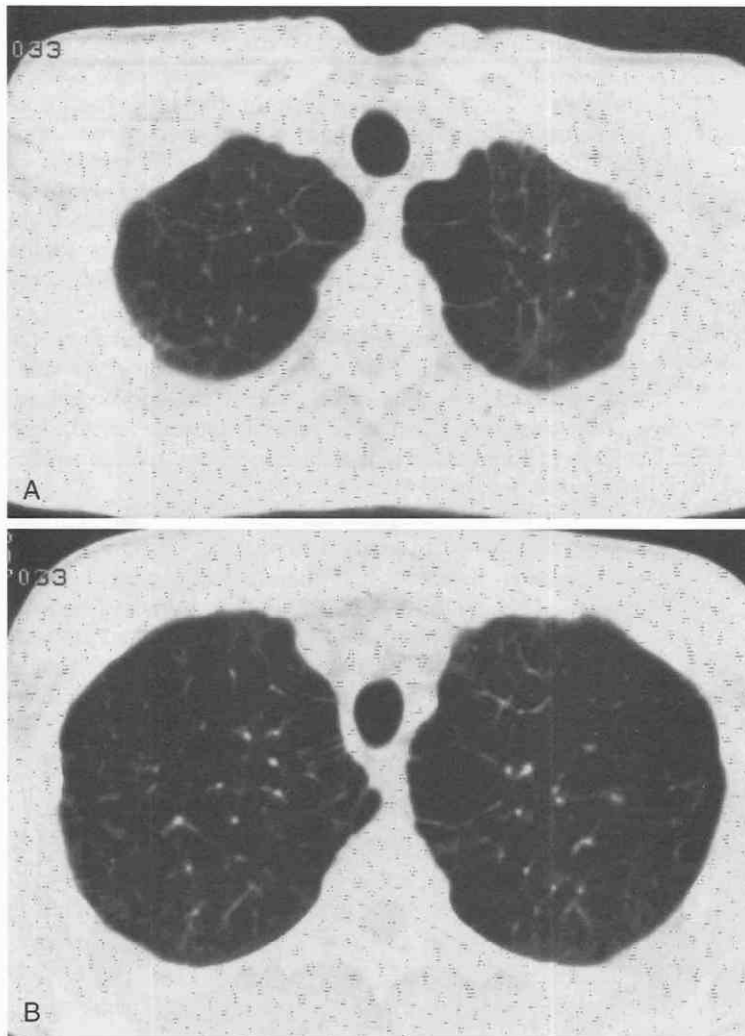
A and B, Panacinar emphysema. High-resolution CT findings of panacinar bullous emphysema include intraparenchymal low-attenuation areas (lung dropout), pulmonary vascular pruning and distortion, abnormally low CT attenuation of the lung, and enlarged air spaces.
